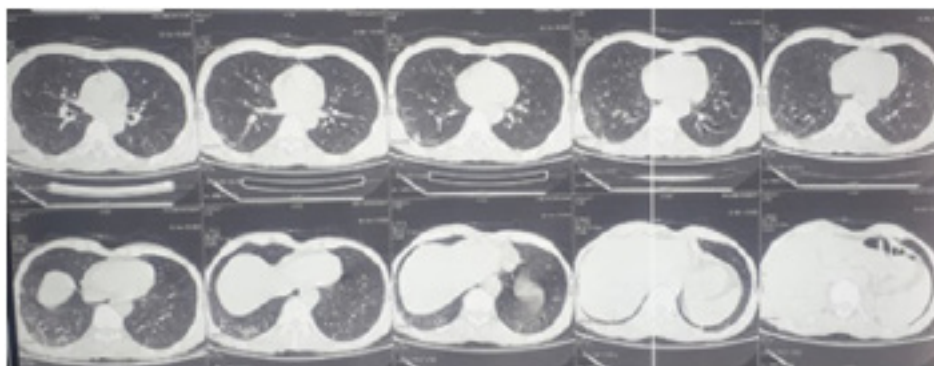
chest CT scan showing ground glass opacifications consistent of SARS-CoV-2 infection.
